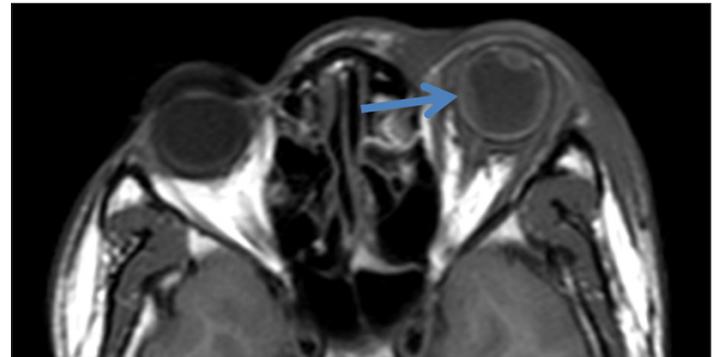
MRI, axial view showing retinal detachment (solid arrow).
